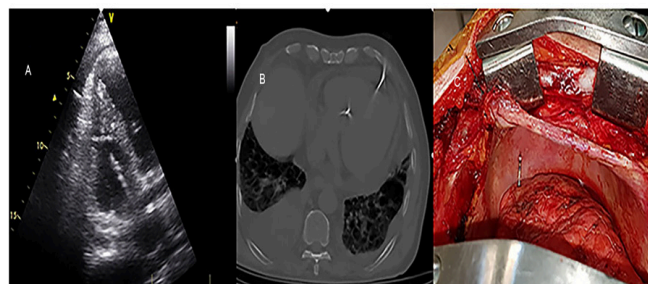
A. Ventricular lead tip outside of the right ventricular cavity on echocardiographic assessment. B. Chest computed tomography depicting lead perforation. C. Surgical view showing the perforating lead
